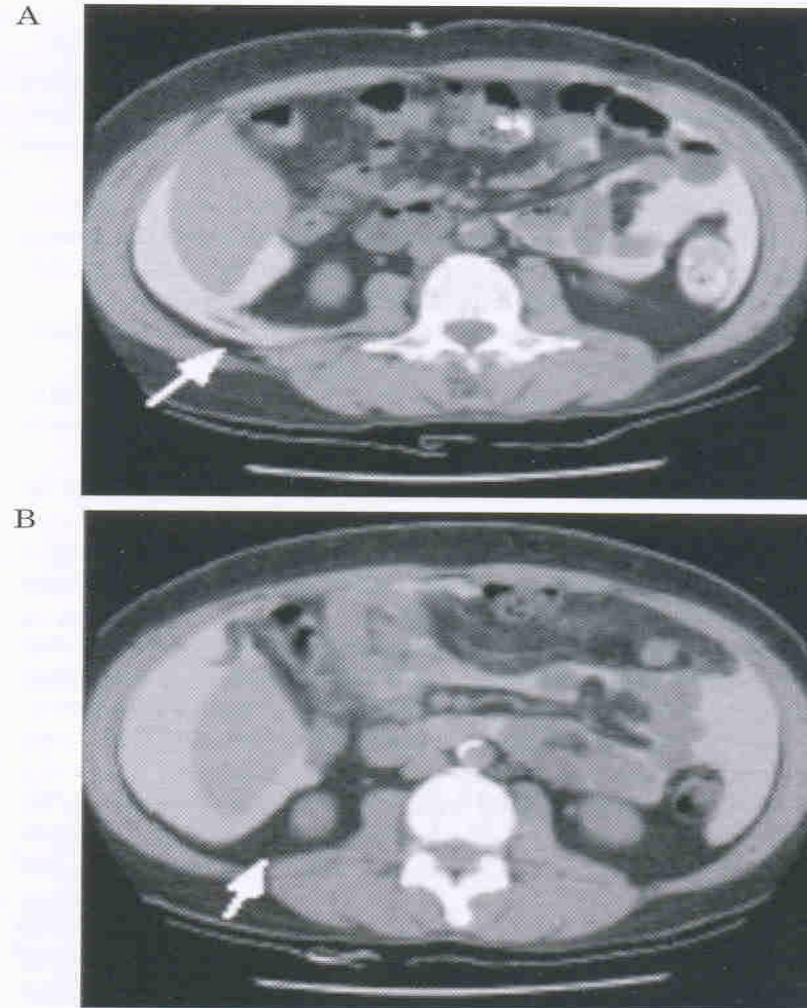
Computed tomographic (CT) peritoneography for Case 3. Retroperitoneal leakage is marked with an arrow (A). Repeat CT peritoneography shows disappearance of the leakage (B).
